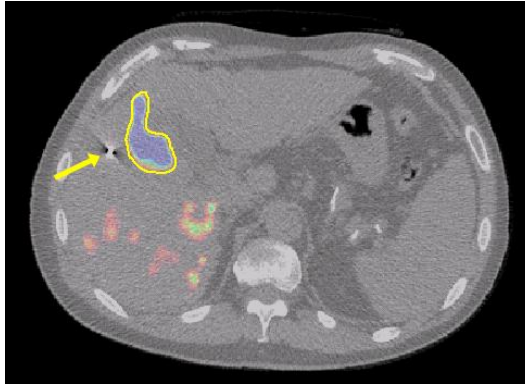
Merged CT and PET images. One fiducial is observable (yellow arrow). The target is delineated (yellow line)
